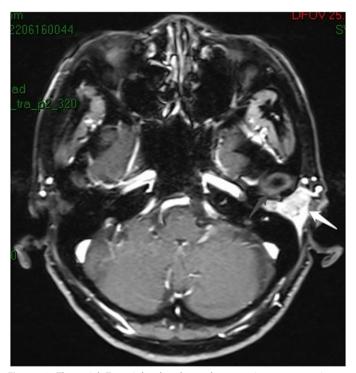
The axial T1-weighted enhanced magnetic resonance image showed T4 adenoid cystic carcinoma in the external auditory canal, tumor predominately locates in the cartilaginous segment (white arrow) and involves the temporomandibular joint anteriorly (gray arrow).
